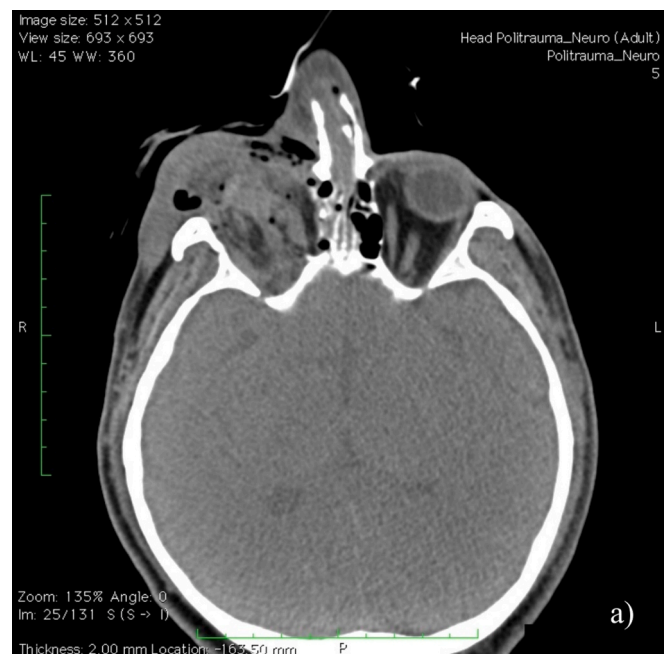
Cranial CT scan (a) performed immediately after the explosion, showing multifragmentary fractures of the orbital walls, bone fragments dislocated intracranially and complete destruction of the right eyeball.
